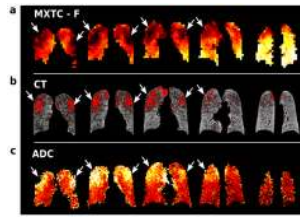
Results from CT and HXe129 imaging methods for COPD subject C2. The three imaging techniques depict emphysema in the same regions of the lung, as decreased parameter values in MXTC-F (a) and CT (b) (parameter values with less than -950 HU are colored in red) and increased parameter values in ADC (c).
